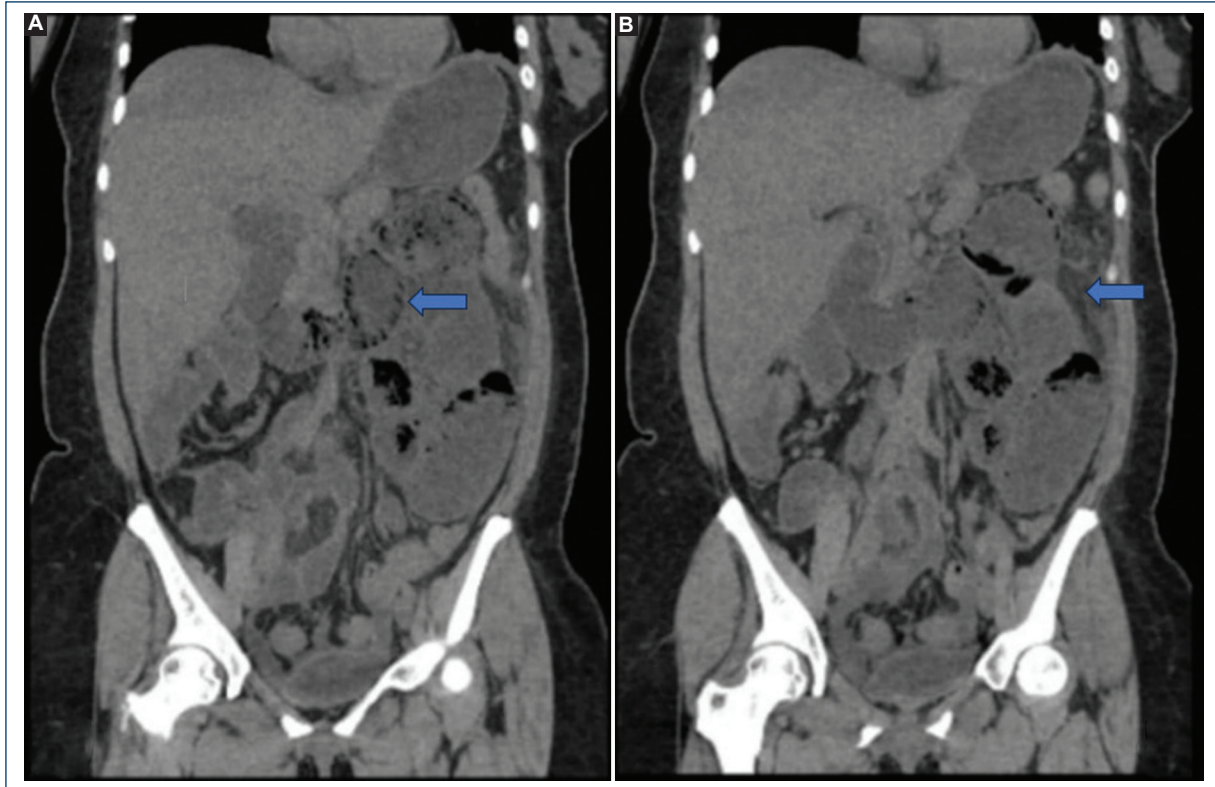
A: coronal section of a simple abdominopelvic CT scan showing pneumatosis at the level of the proximal jejunum and B: striation of the peri-caecal fat at the level of the splenic angle.
